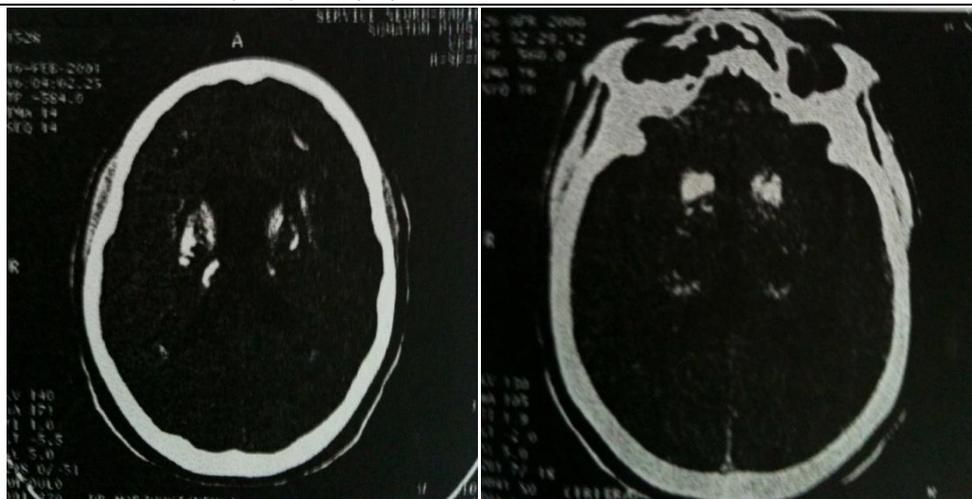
Computed tomographic images of observation n° 2
